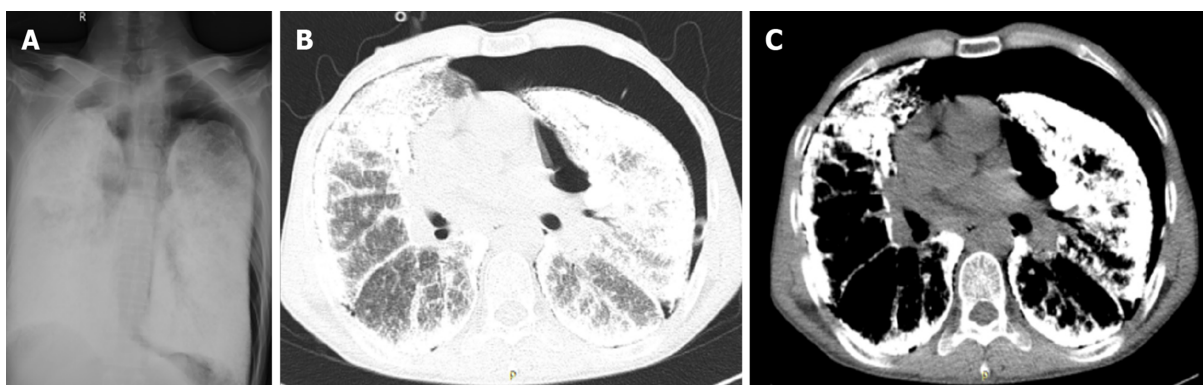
Preoperative imaging results suggestive of pulmonary alveolar microlithiasis. A: Chest X-ray image showing bilateral, diffuse, symmetrical, sandstorm-like radiopaque micronodules and pneumothorax; B: Chest computed tomography (CT; pulmonary window) image showing decreased diffuse transmittance; C: Chest CT (mediastinal window) image showing calcified, minute miliary nodules in both lungs.
